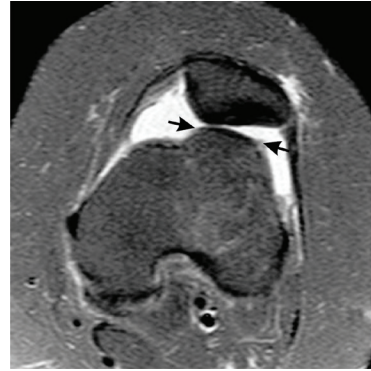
T2-weighted MRI with fat suppression in the axial plane, showing dysplastic trochlea characterized by a convex lateral facet (arrows).
